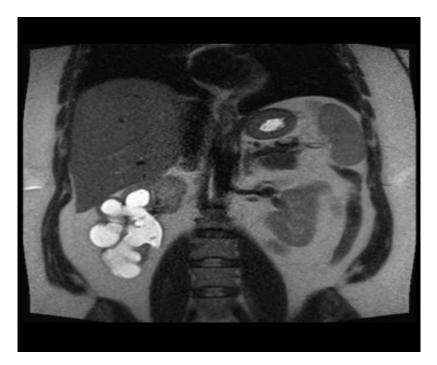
MRI coronal section T 1 W image for kidney (William et-al, 1992).
